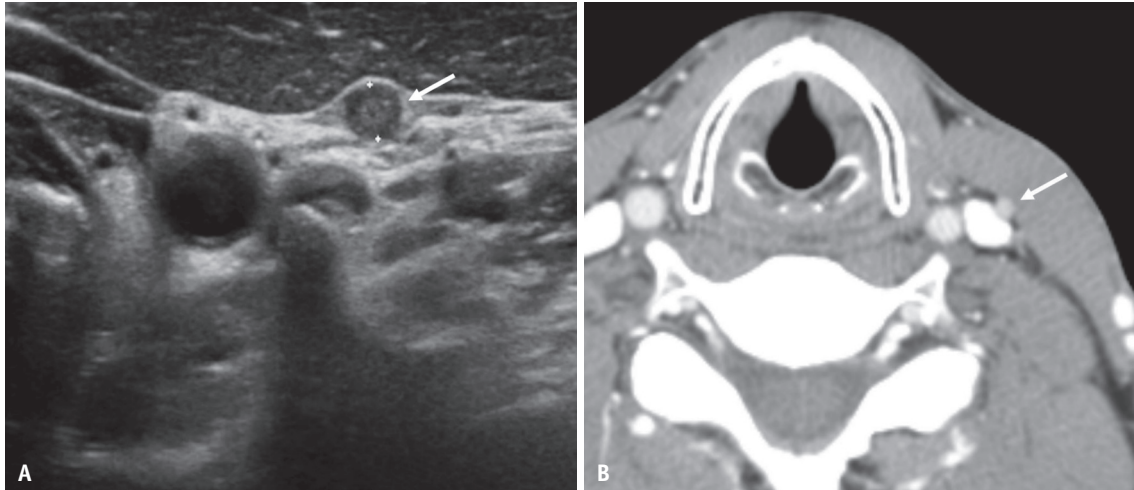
A 65-year-old female with left papillary thyroid carcinoma. A small lymph node (3 mm in short diameter) at the left level III showing suspicious features of hyperechogenicity on US (arrow) (A). Strong enhancement is noted on axial contrast-enhanced CT (arrow in B) and is classified as suspicious LN. Fine-needle aspiration confirmed a metastatic papillary thyroid carcinoma. US = ultrasound, CT = computed tomography, LN = lymph node
